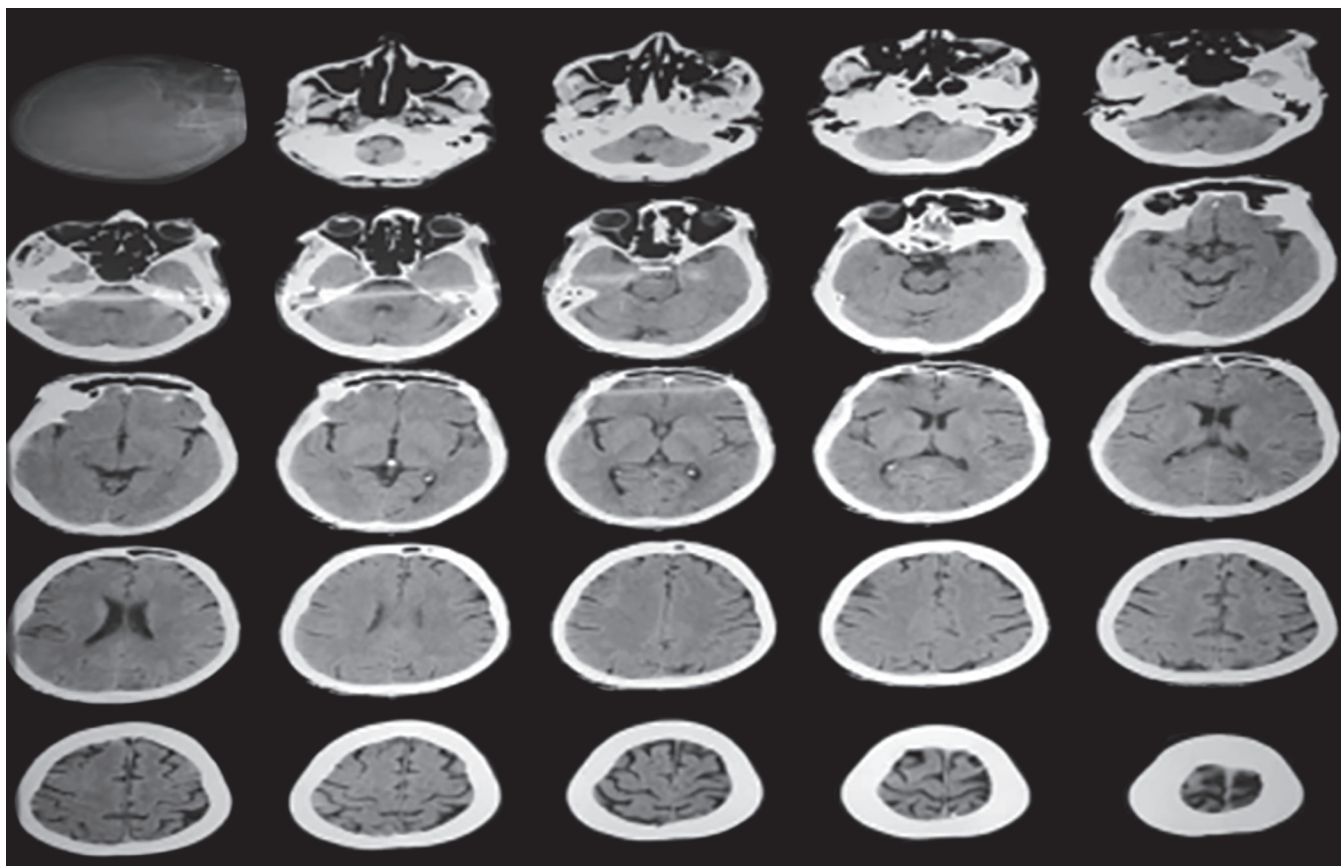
Normal CT scan of brain
